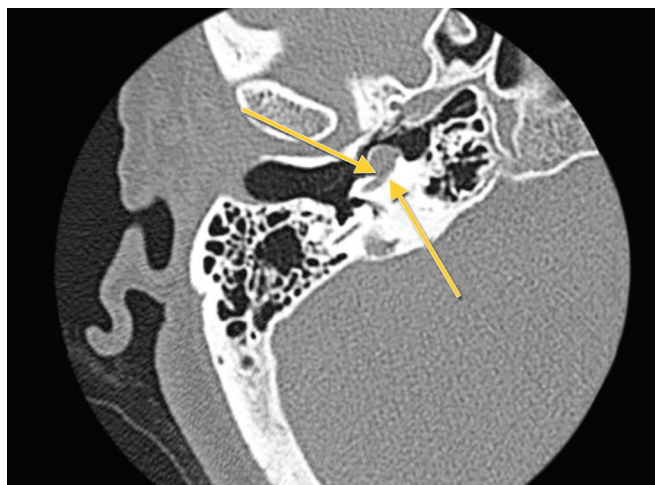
Computed tomography (CT) scan (axial section) of the right ear. The vertical segment of the petrous internal carotid artery is dehiscence (arrows) into the basal turn of the cochlea. *Source:* Adapted with permission from Lund and Palacios.²⁷
